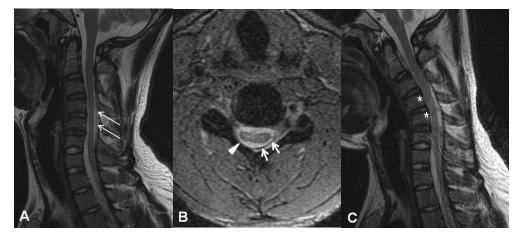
A. T2-weightedsagittal MRI taken in neutral position of the neck shows reversed curvature, focal cord atrophy and slight signal change of the spinal cord at C4 and C5 level. There is detachment of posterior dura shown by thin arrows. B. An axial gradient MRI at the level of C5 demonstrates an asymmetric atrophy of the spinal cord (arrowhead) and a loss of attachment of the posterior dural sac (thick arrows). Atrophy at the spinal cord is more in the right, whereas detachment at the dural sac is more in the left. C. T2 weighted sagittal MRI, acquired during neck flexion, shows exaggeration of detachment, anterior shift of posterior dural sac and compression of cord against the posterior border of vertebral body, also maximally in C4, C5 level (asterisks).
